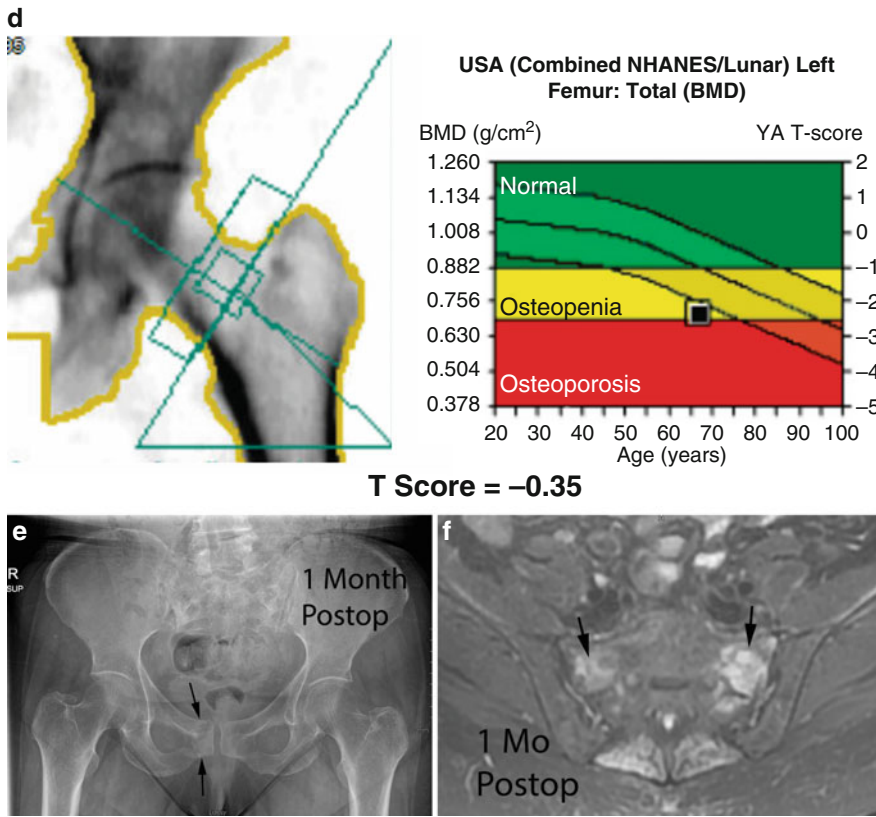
(a) A 69-year-old female presents with neurogenic claudication from L2 to L5. Spinal stenosis is seen on T2-weighted MRI (arrows). (b) Her bone quality appears poor on anteroposterior radiographs. She was diagnosed 6 months earlier with osteoporosis but was untreated. (c) The spine DXA shows normal bone mineral density but should be ignored given her degenerative spinal disease. (d) The proximal hip DXA shows osteoporosis with a
